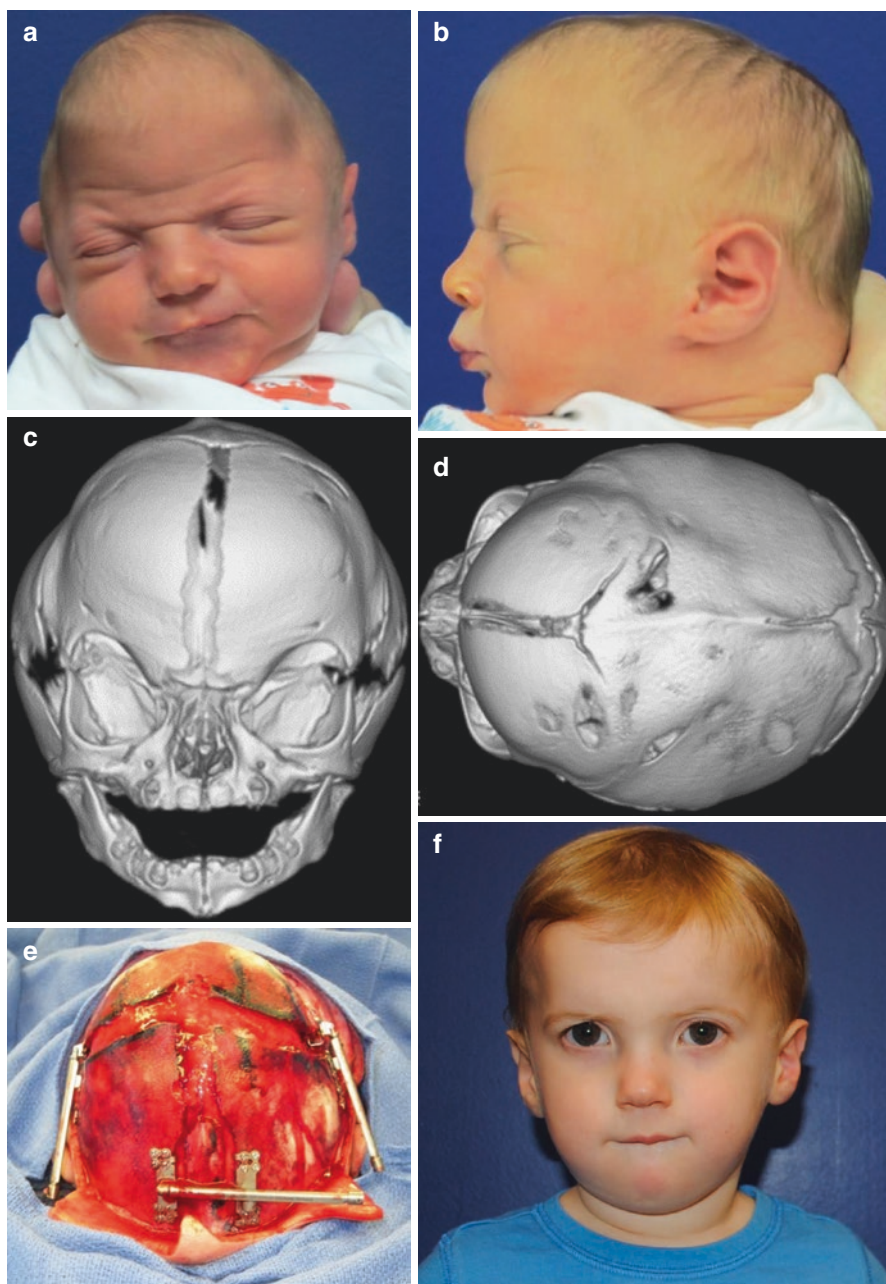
Six-week-old male with bicoronal and sagittal craniosynostosis (a, b). Preoperative CT scan (c, d). Intraoperative photo demonstrating osteotomies and device placement (e). Eighteen-month postoperative appearance (f-h)
